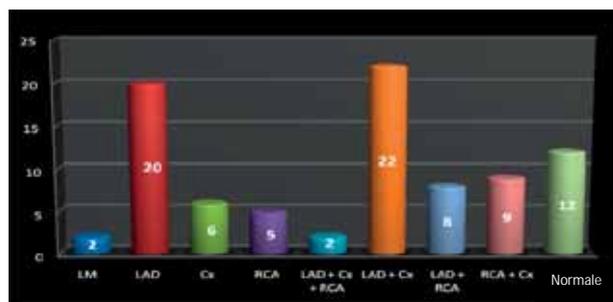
Involvement of coronary arteries obtained by dobutamine stress echocardiography (DSE) in all patients
